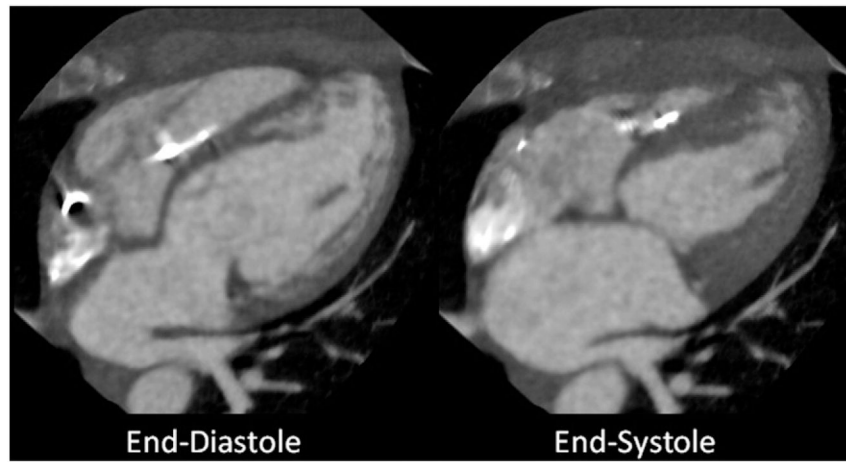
46 year old (BMI 19.6) with congenitally corrected transposition of the great arteries, complete heart block with dual chamber pacemaker and inadequate echocardiographic windows. Four-chamber view demonstrating typical image quality at end-diastole and end-systole with an effective radiation dose of 0.27 mSv.
